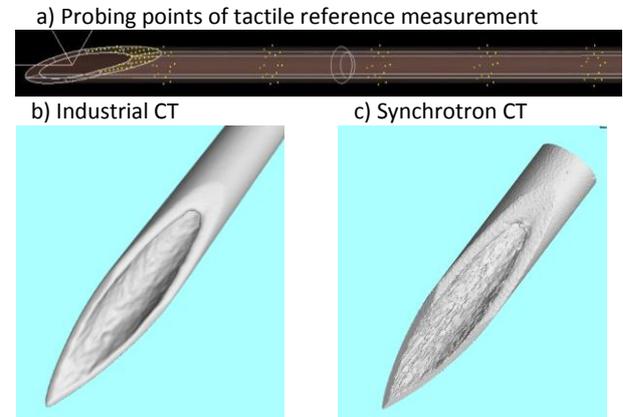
Graphical representation of the measurement results. a) Location of tactile measurement points, b) result achieved with industrial CT 1 (tip region only), c) result achieved with synchrotron CT.
